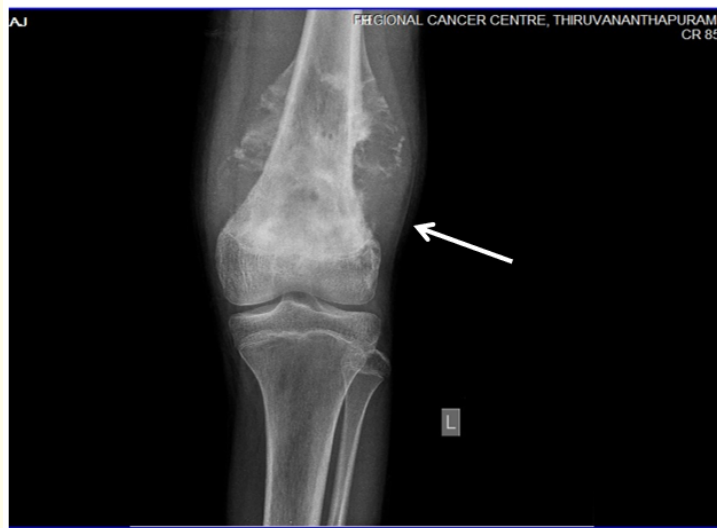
Osteosarcoma -X-ray left femur showing periosteal reaction, Codman's triangle.
